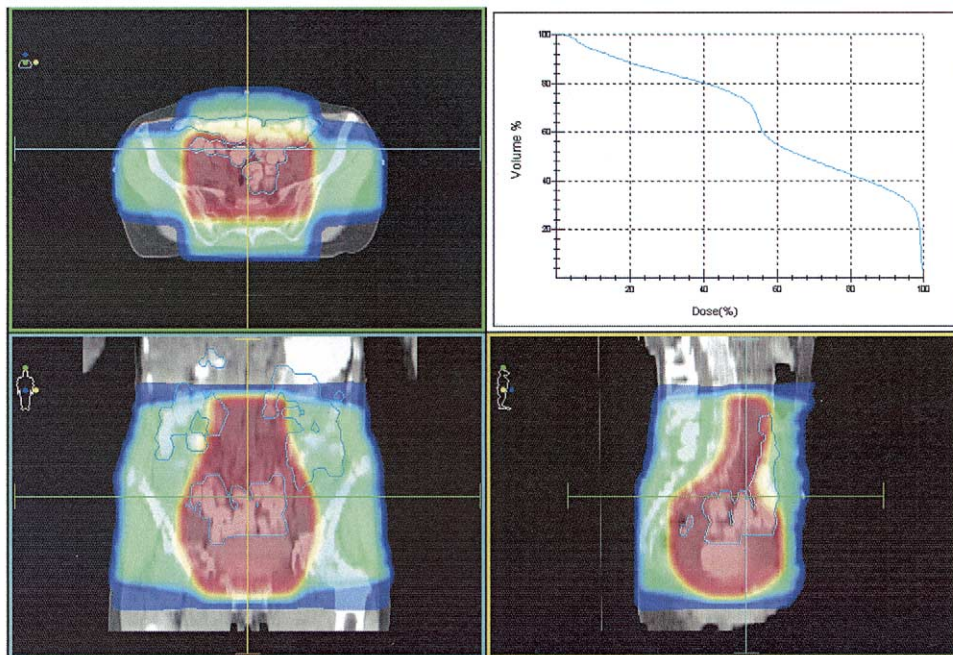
Assessment of dose and volume parameters using a computed tomography scan in treatment position and 3D treatment planning software. Transverse, coronal, and sagittal plane reconstructed slices are shown, respectively. The light blue contour represents the small-bowel contour. The relative dose distribution is presented by means of a color wash with the red area representing a dose $\geq 50\%$ of the prescribed tumor dose, i.e., the tissue located actually within the irradiation fields. The upper right panel shows the corresponding small-bowel dose-volume histogram. *Patient 4:* Cervix carcinoma. External radiation treatment delivered by means of 4-field box technique to the primary tumor, pelvic, and lower para-aortic lymph nodes. Upper level L2–L3, Daily fraction dose 2 Gy. Total tumor dose prescribed 46 Gy in 4½ weeks. Mean SB dose 31 Gy. SBV50% = 74%.
